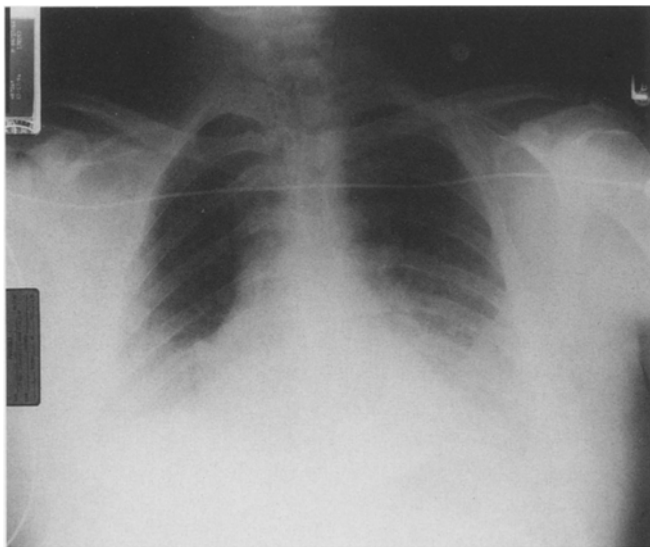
Chest radiograph revealing bilateral interstitial and alveolar infiltrates in the lower lung fields
